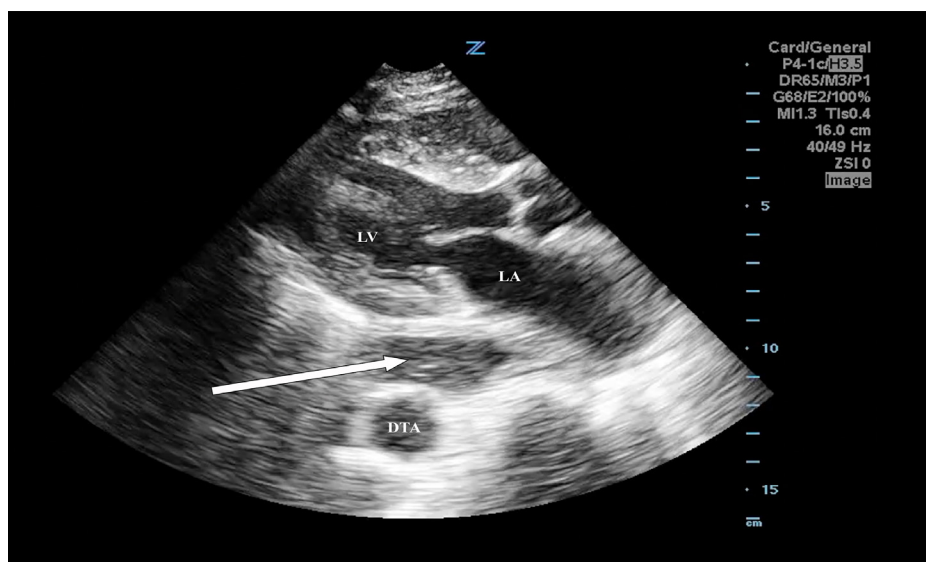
Parasternal long-axis window with anechoic mass (arrow) with microbubbles posterior to the left atrium (LA) and left ventricle (LV) but anterior to the descending thoracic aorta (DTA). Despite mimicking life-threatening aortic pathology, this is a fluid-filled hiatal hernia.
